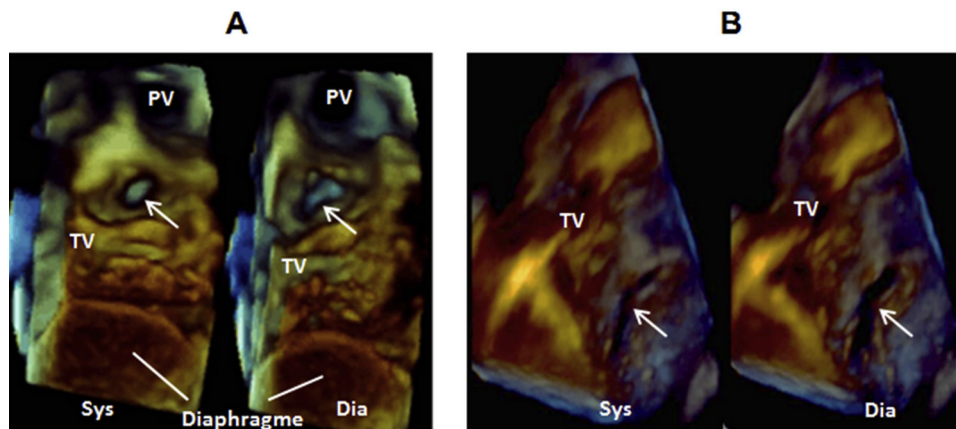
Right ventricular 3D transthoracic echocardiographic en face view of a membranous (A) and a muscular (B) VSD surface area (arrows) displaying variation of morphology during the cardiac cycle. *Dia*, Diastole; *PV*, pulmonary valve; *Sys*, systole; *TV*, tricuspid valve.
